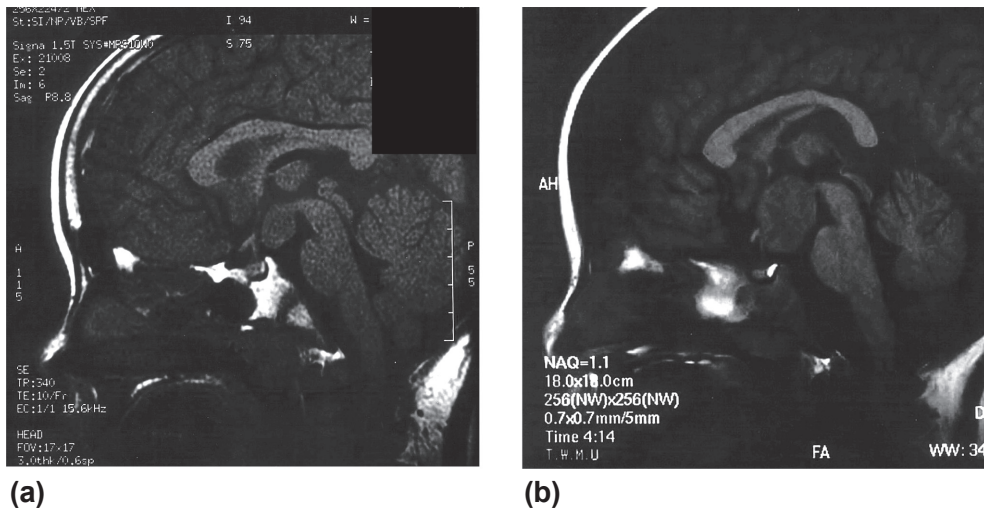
MRI findings (T1-weighted sagittal images) from cases 1 (a) and 2 (b). The lesions (1.2×1.5 cm in Case 1; 2.0×2.5 cm in case 2), which are protruding into the interpeduncular cistern, are isointense to gray matter and distort the third ventricle.
